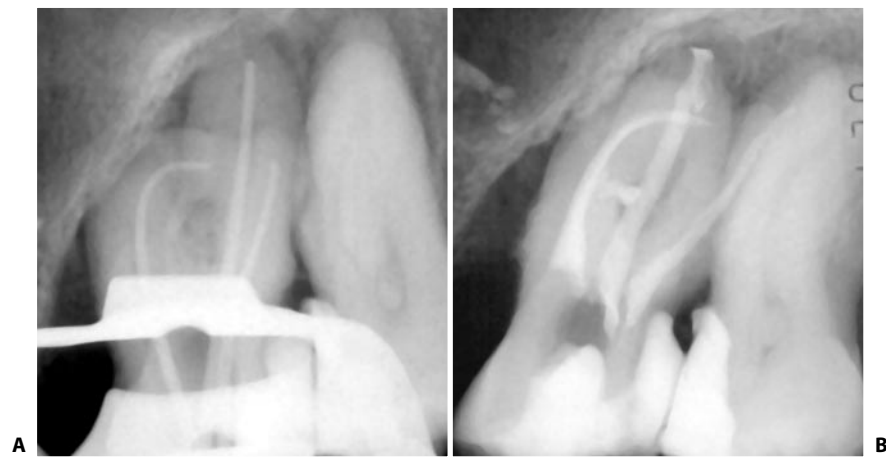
Endodontic treatment of an upper second molar; the mesio-buccal root has a very accentuated curvature. A. Cone fit radiograph. B. Postoperative radiograph: obturation carried out using the Microseal Technique. One notes the obturation of a lateral canal in the middle third of the mesio-buccal root.
